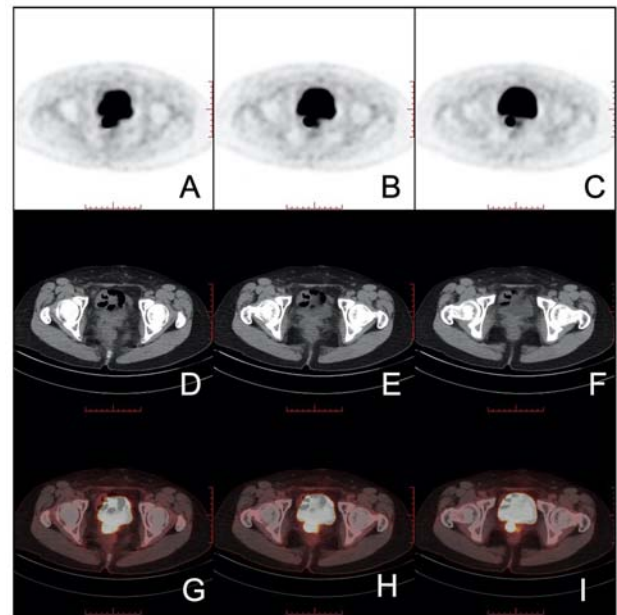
Representative PET/CT scan images of postoperative tumor recurrence and metastases of a patient with cervical cancer. (A-C) PET images. (D-F) CT images. (G-I) Fusion images of PET and CT images. The patient was 44 years old. In the upper right side of the vaginal stump, an irregular and slightly low-density mass shadow is seen, the uptake of imaging agent (^{18}F -FDG) is increased, and the boundary between the mass and bladder and rectum is unclear. PET, positron emission tomography; CT, computed tomography.
